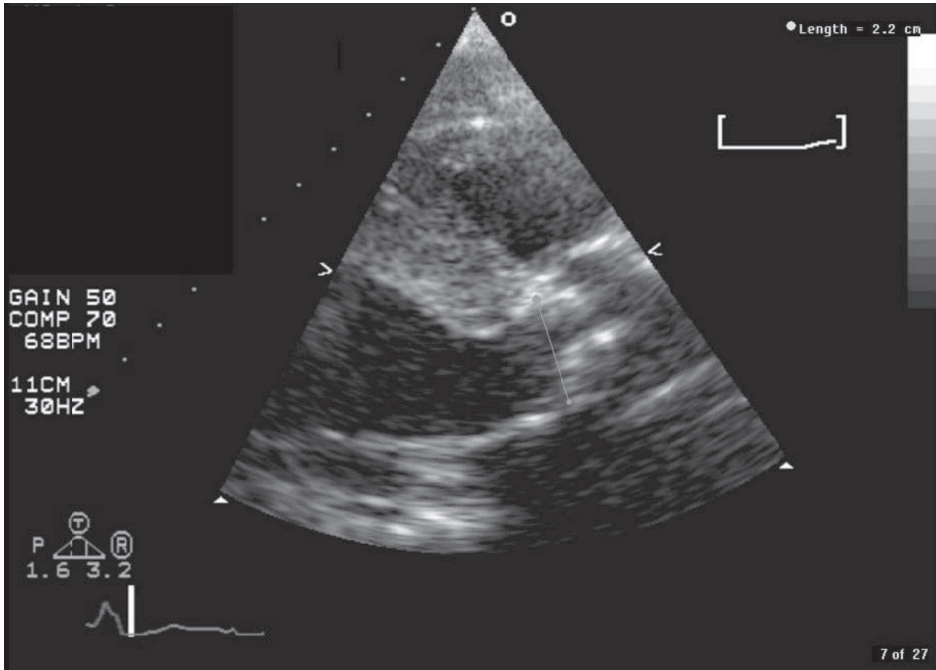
Transcatheter aortic valve implantation requires non-invasive estimation of the size of the annulus. One method is to estimate the diameter of the aortic annulus from a transthoracic long axis echocardiogram. Typically the measurement is made at the ventricular aspect of the leaflet insertion.
